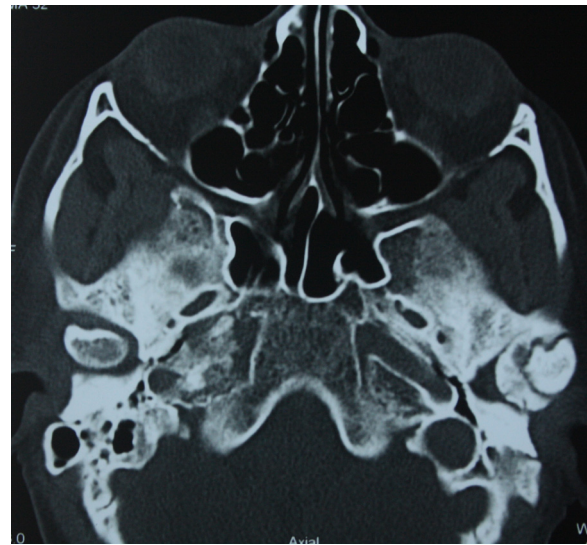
The present CT scan axial cut showing the ankylotic mass on left side.
